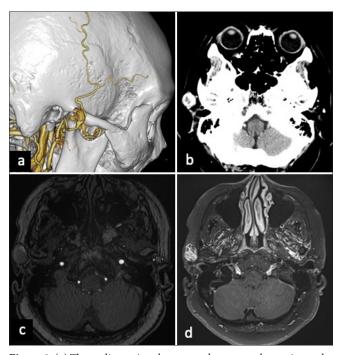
(a) Three-dimensional computed tomography angiography revealed an aneurysm of the right main trunk superficial temporal artery and (b) the dorsal side of the aneurysm showed thrombosis with heterogenous enhancement. (c) Magnetic resonance images showed a signal of a superficial temporal artery on the ventral side of the aneurysm and (d) the thrombosed area showed heterogenous enhancement same as computed tomography.
